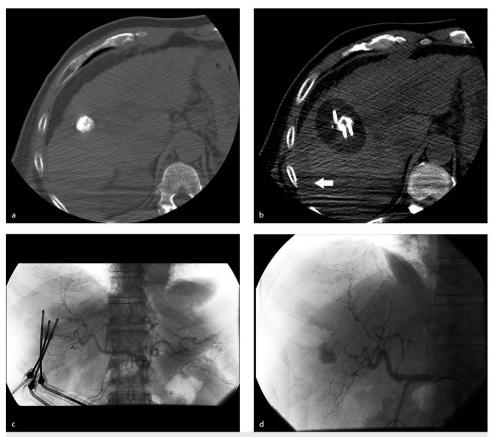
Scout CT image (a) shows good ethiodol uptake in the previously treated right liver cancer, prior to placement of three cryoablation probes. After probe placement, and at the end of the second freeze cycle, a subtle subcapsular hematoma is discovered on the penultimate monitoring CT scan (b, white arrow). The patient is taken to the angiography suite with the probes left in situ. Angiograms before (c) and after (d) probe removal show no arterial contribution to the hematoma. This patient was successfully treated with transfusion medicine alone.
